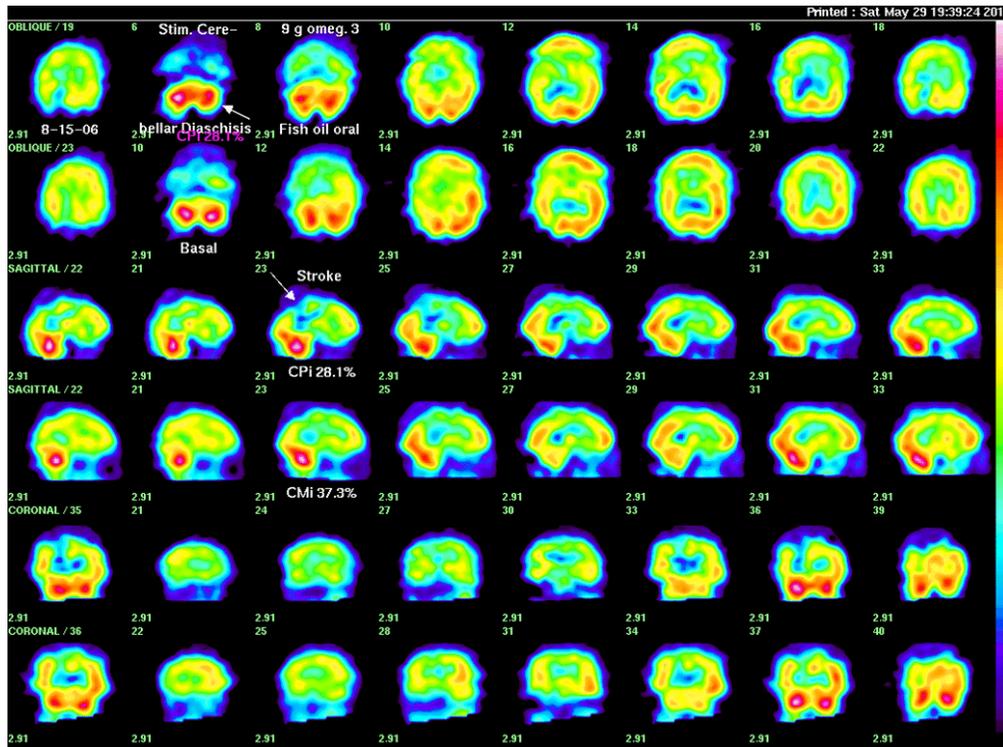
Above is SPECT for an 86 year-old woman with renal failure, serum creatinine 2.6 mg/dl, cystatin C 2.75 mg/L, and GFR 22 ml/min, exemplifies exception to the usual preservation of FRi with renal failure which is usually observed prior to stroke. The top row of each set of 3 paired images is post perfusion stimulation, using 10 g of fish oil in this case, which we have repeatedly shown is similar to either acetazolamide IV or nitroglycerin sublingual. A right posterior parietal stroke is easily appreciated. Saggital image 23 shows further decreased perfusion in the penumbra area as compared to the basal images below.
